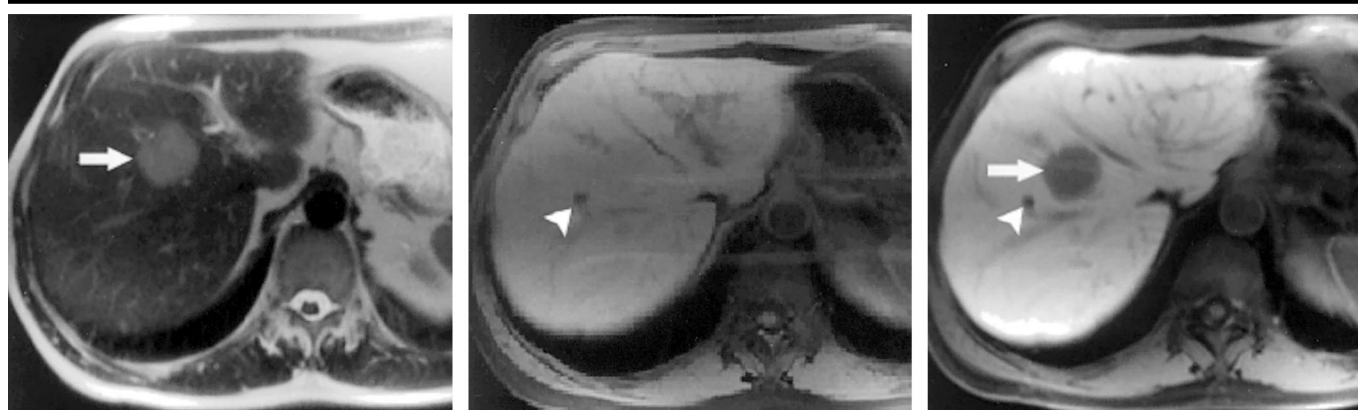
Transverse MR images of the liver obtained at 1.5 T show metastasis of thyroid carcinoma in a 53-year-old man. (a) Nonenhanced half-Fourier single-shot turbo spin-echo image (4.4/64; flip angle, 140°) shows a central, moderately hyperintense lesion (arrow) in segment VIII. (b) On a T1-weighted fat-saturated image (124/4.1; flip angle, 75°), the lesion is not clearly depicted. (c) On an image obtained 20 minutes after administration of 0.025 mmol/kg of gadoxetic acid with the same parameters used to obtain b, the increase of liver-to-lesion contrast allows clear delineation and localization of the lesion (arrow). Note the additional small cyst (arrowhead) in segment VIII depicted in b and c. In a, the lesion is depicted in an anatomically inferior section. Artifacts of nonuniform signal intensity caused by coil geometry are visible in anterior and posterior portions of the liver on b and c.
